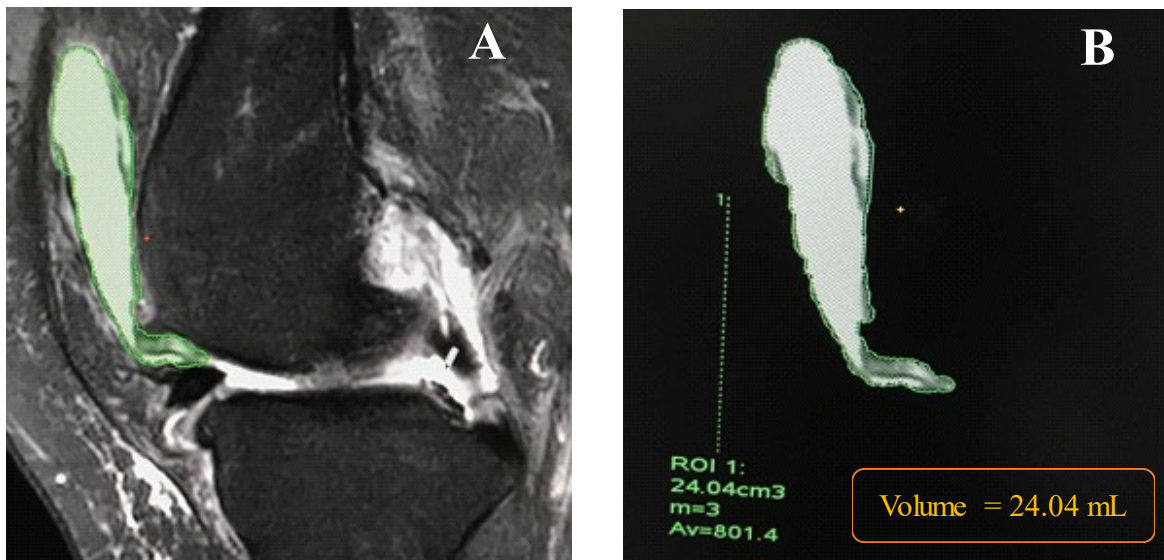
(A) Sagittal T2FS of MRI knee, showing the area of high signal intensity with superimposed color data as green. (B) ROI was placed according to intra-articular fluid in the suprapatellar recess and the total volume was generated from the entire series of images using GE AW Volumeshare 5 software.
